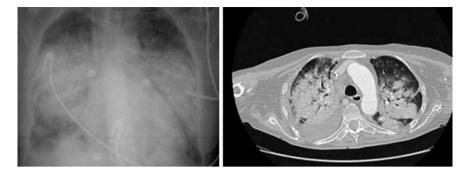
Systemic disease visualised by thoracic radiography (left) and a thoracic scan (right)
